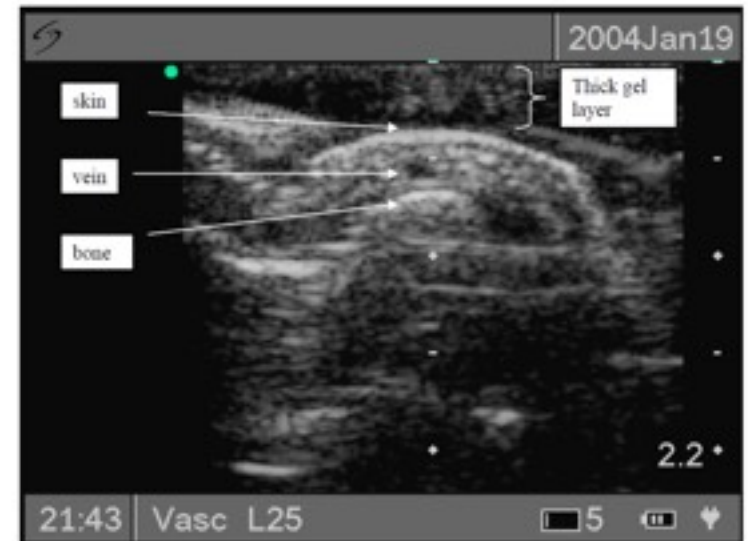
Ultrasound image of target vessel
